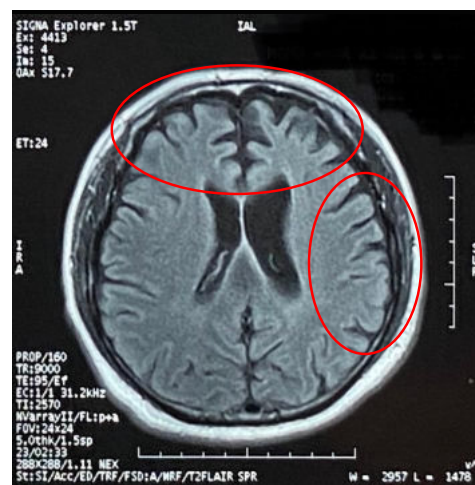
Brain magnetic resonance imaging showing cerebral atrophy over the bifrontal and left temporal lobes.
